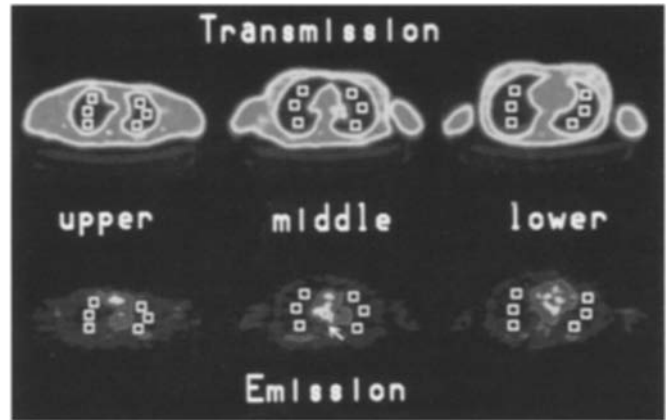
Multiple 6×6 pixel ROIs are positioned in the anterior, mid, and posterior portions of the upper, middle, and lower lung fields. ROIs were positioned first in transmission images then copied onto spatially registered emission images at the same level. The arrow indicates the intense uptake of FDG in the area of a squamous cell carcinoma (patient 11)
